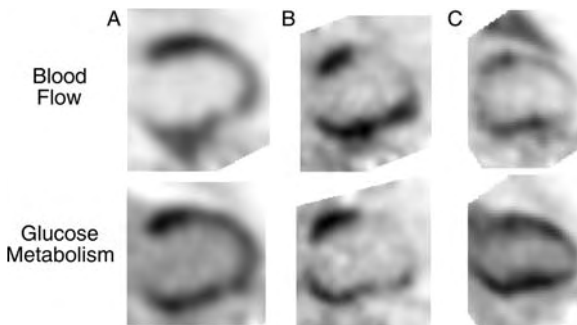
Patterns of myocardial blood flow and glucose metabolism (as obtained with ^{13}N -ammonia and ^{18}F -deoxyglucose PET) in 3 patients with ischemic cardiomyopathy and poor left ventricular function. Only vertical long axis cuts through the mid-left ventricle are shown. Patient A demonstrates an enlarged left ventricular cavity with a mild decrease in perfusion in the anterior wall, apex, and the distal inferior wall. Glucose metabolism is homogeneous and exceeds perfusion in the anterior wall. In patient B there is a severe perfusion defect in the akinetic anterior wall that is matched to the glucose metabolic images by showing a decreased uptake of FDG referred to as “match” pattern. In contrast, in patient C, there is an extensive perfusion defect involving the anterior wall and the apex. However, the glucose metabolic images demonstrate preserved FDG uptake in the anterior and distal anterior wall. This pattern is referred to as a “blood flow / metabolism mismatch”
